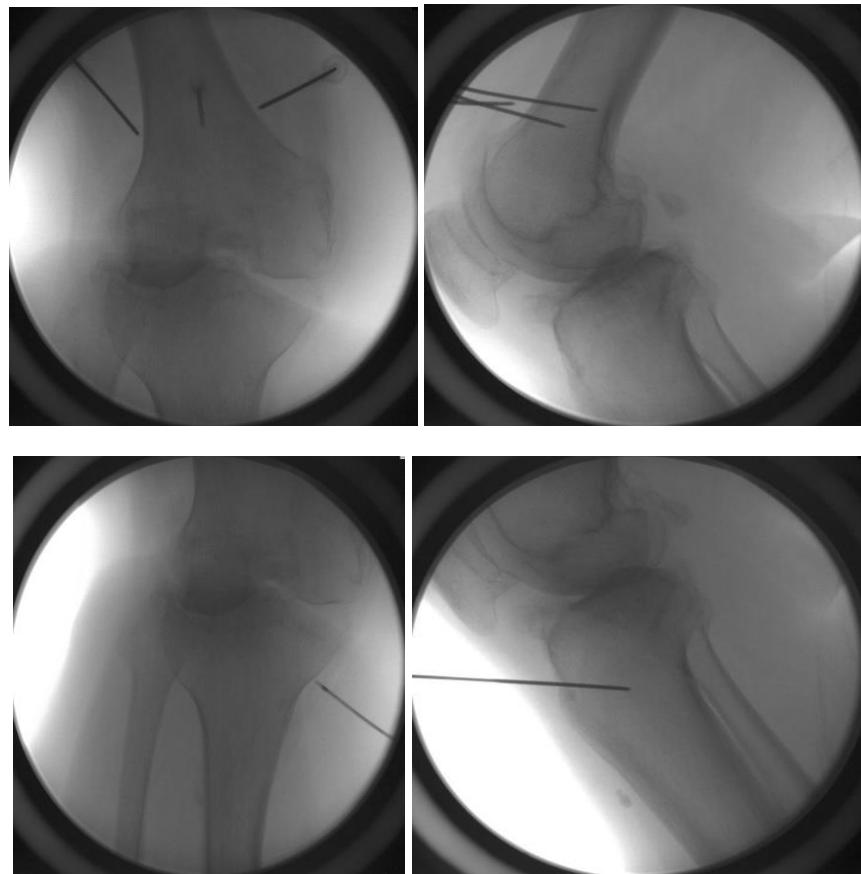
Knee radiograph, Anteroposterior view
